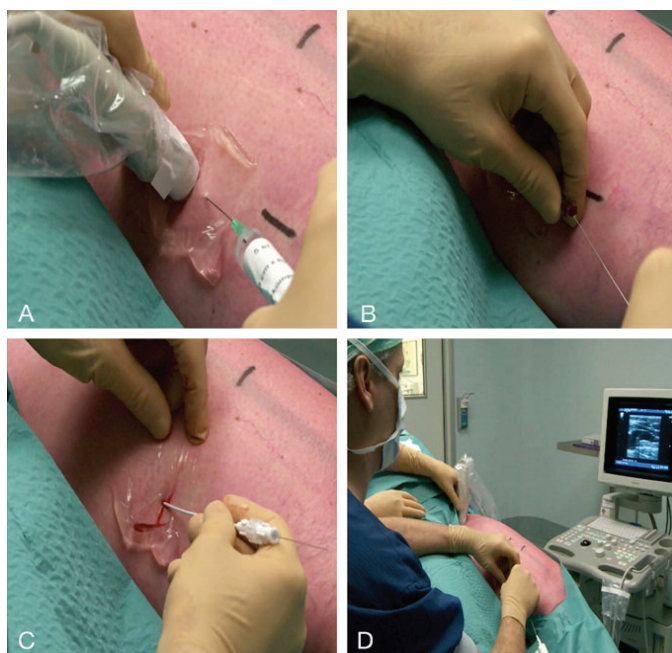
After the introduction of local anesthesia (A), the vein is punctured and subsequently the guidewire (B) and sheath (C) are introduced. Then the ClariVein® catheter is introduced under ultrasound guidance (D).
